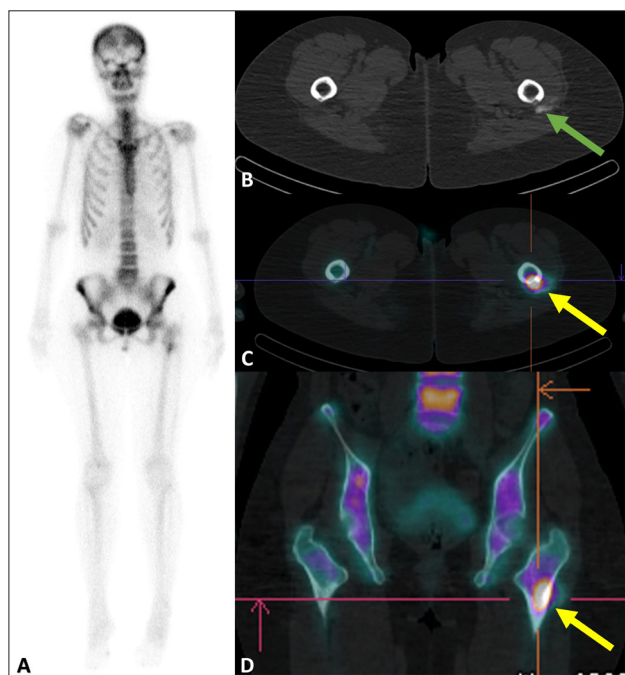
Anterior planar image (A), axial low-dose CT (B), and axial (C) and coronal (D) SPECT-CT images, performed one month after symptom onset, demonstrate increased tracer uptake in the left proximal femur (yellow arrows), corresponding to the faint, ill-defined calcification on B (green arrow).
